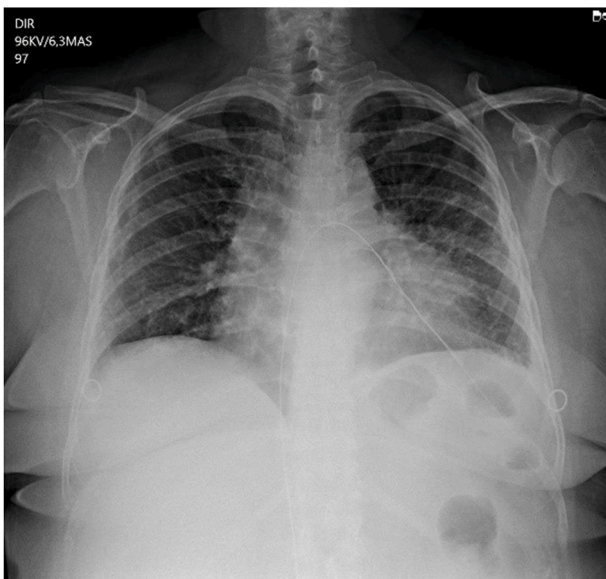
Chest X-ray showing a guidewire shaft in inferior vena cava topography and distal extremity in the left hemithorax.
